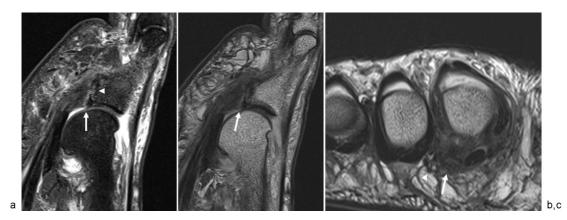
A 66-year-old woman presents with a 3-month history of pain and swelling at the central forefoot. (a) Sagittal fat-suppressed protondensity (PD) and (b) PD MR images through the lateral plantar plate of the second MTP joint demonstrate severe degeneration and nonretracted tear at the proximal phalangeal insertion, with adjacent entheseal bony irregularity and mild bone marrow edema at the base of the proximal phalanx. Note the associated joint effusion and mild synovitis. (c) Short-axis T2 MR image demonstrates pericapsular fibrosis at the plantar lateral margin of the lateral plantar plate (arrow), displacing the normal-appearing plantar digital nerve (arrowhead).
